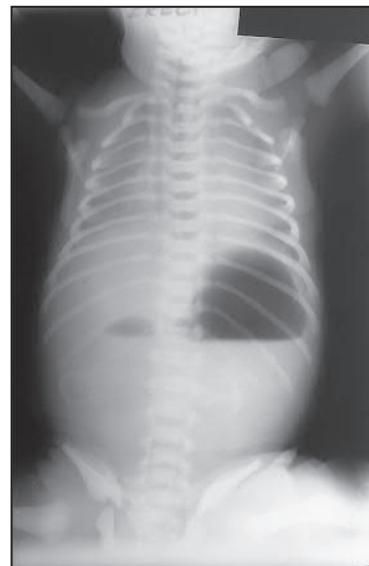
Abdominal X-ray in duodenal atresia showing a 'double bubble' from distension of the stomach and duodenal cap. There is absence of air distally.
